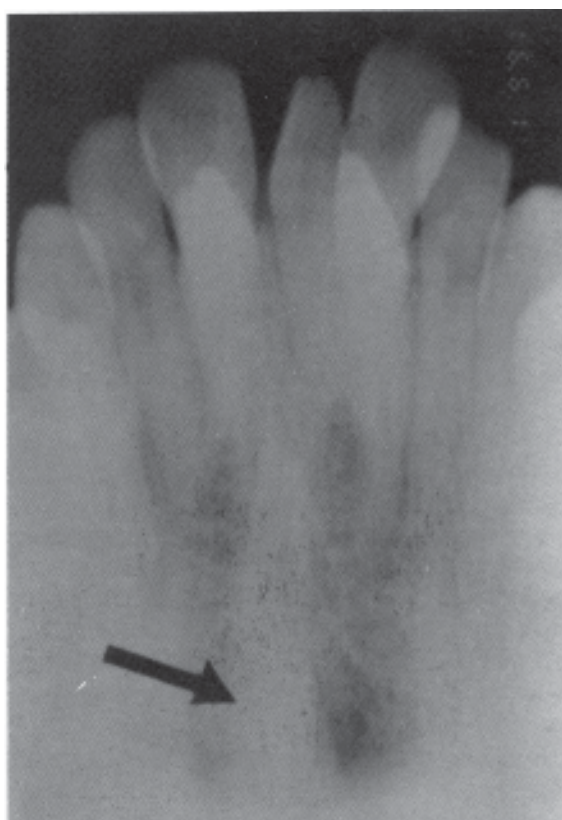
Upper anterior occlusal radiograph of Case 2 showing the 4th inverted but conical-shaped supernumerary tooth impacted in the midline (arrowed).
